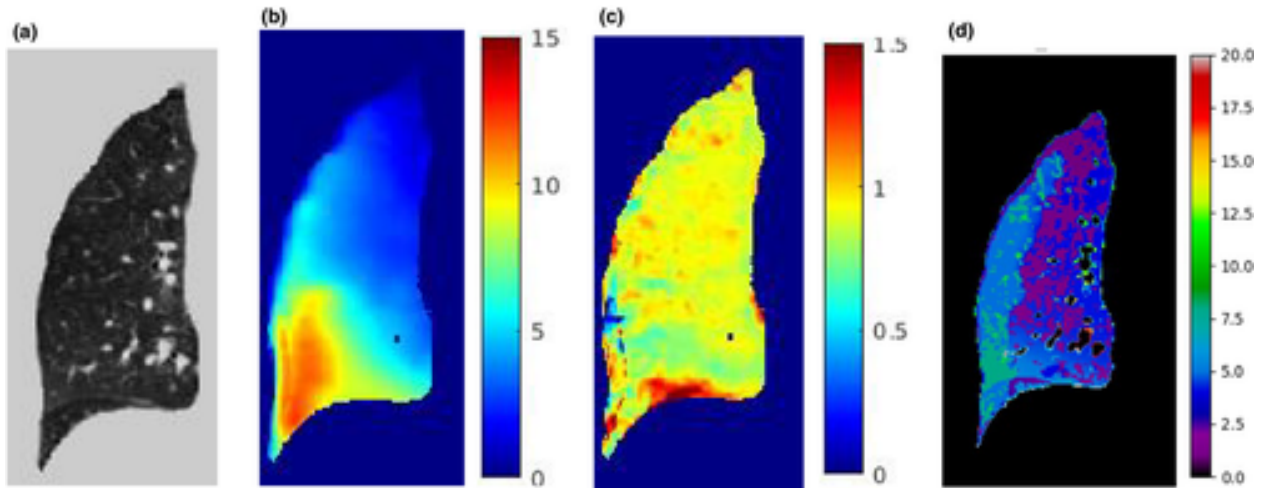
(a) The lung computed tomography (CT) geometry, (b) the underlying displacement magnitude (in mm), and (c) the Jacobian distribution are shown. (d) Shows the elasticity estimation associated with the lung CT (in kPa)
